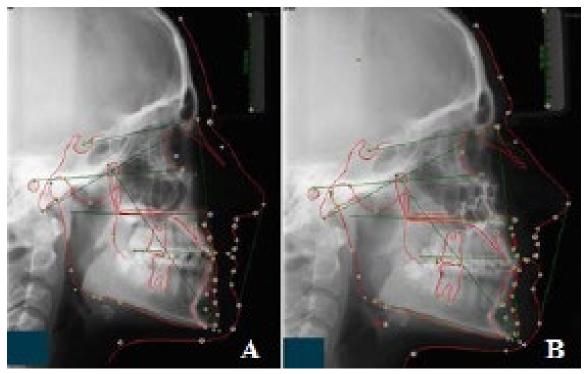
Lateral cephalometric radiographs of patient with surgery (a) Pre-treatment (b) Post-treatment.
